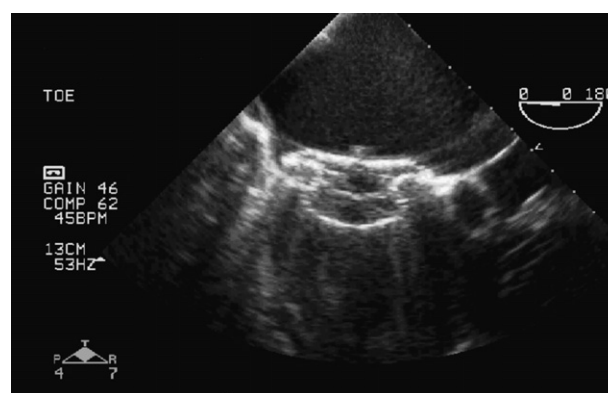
Transoesophageal echocardiogram showing Amplatzer Septal Occluder across the atrial septum.
